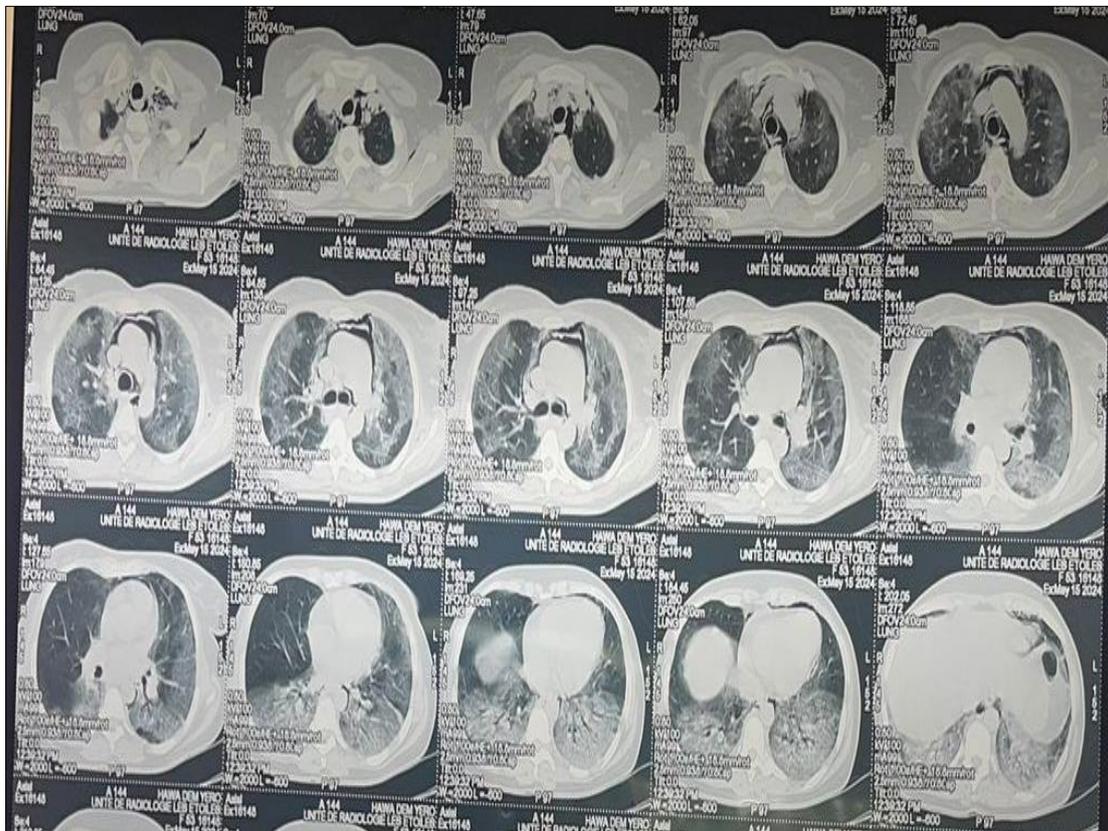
Patient's chest CT-Scan (Dr Stéphane L Djeugoué – Dr Tientcheu T Dorette)
